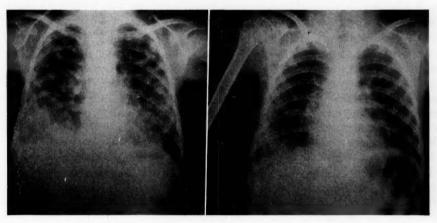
Contrast in chest x-rays taken before roentgen therapy and three months afterward in a case of Ewing's tumor at the age of 7 years.
